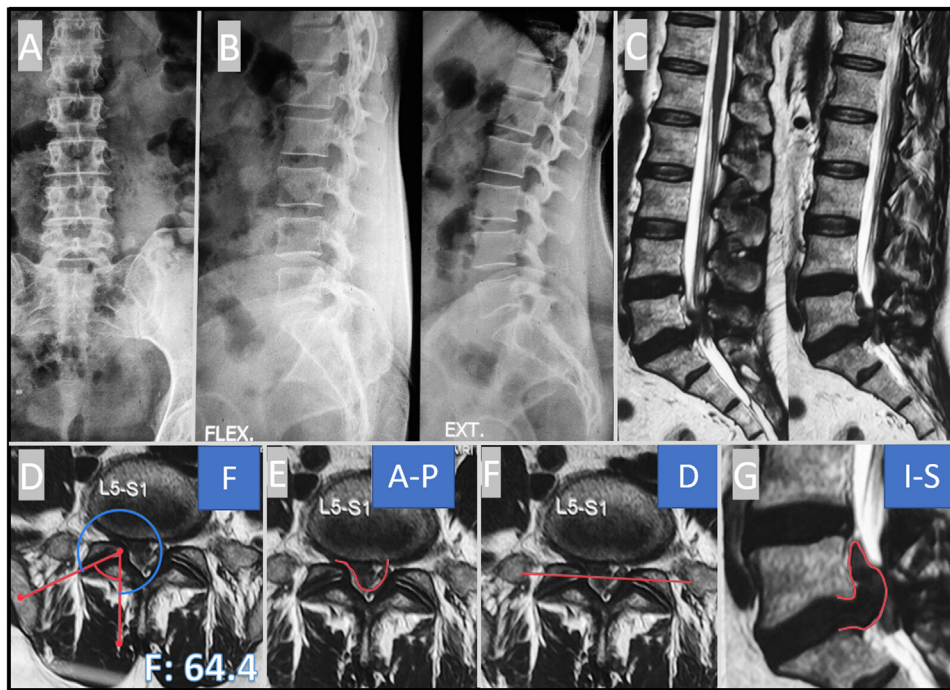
FAPDIS description of interlaminar approach – A and B (X-ray LS Spine AP and Lateral): showing stable spine. (C) Sagittal T2 MRI showing Dorsal and superior disc extrusion at L4/L5 level. (D–G) (FAPDIS Calculation) : (D) Facet angle 64.4 (F3). (E) Anterior disc pathology without any posterior offending pathology. (F) Dorsal far soft disc herniation. (G) Inferior far disc herniation (FAPDIS calculation F3A1A2PODfsvf; Total score (TF:IL = 3: 5).
